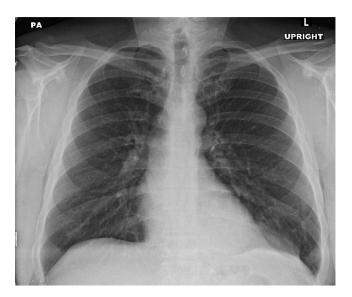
Chest radiograph demonstrates an opacity in the left lower lobe.
